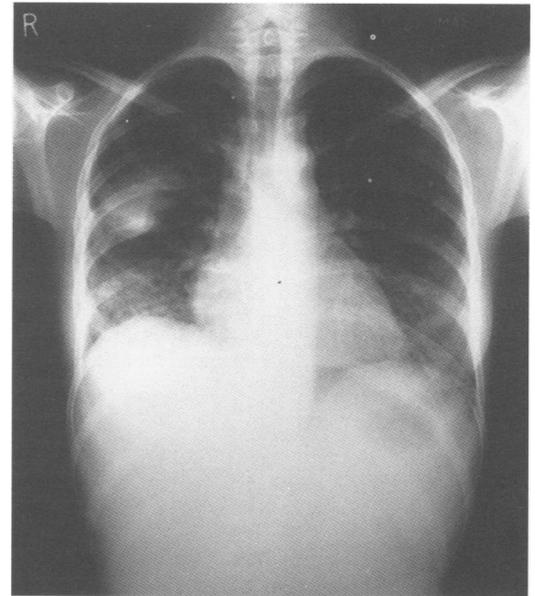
Chest radiograph three weeks later showing only small areas of consolidation in the right upper and lower lobes.
